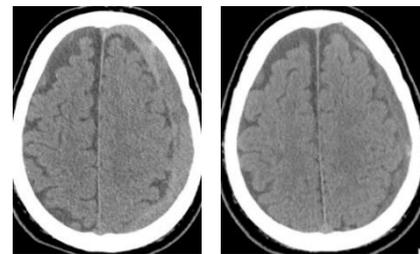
Left: Non-contrast CT head after 4 weeks of steroid therapy, demonstrating persistence of the left CSDH. Right: Non contrast CT head done at 6 months follow up demonstrating near resolution of the left CSDH.
